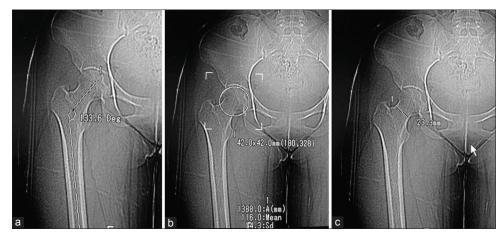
Sagittal CT scan of hip with thigh showing (a) Neck shaft angle (b) Head diameter (c) Width of the femoral neck
